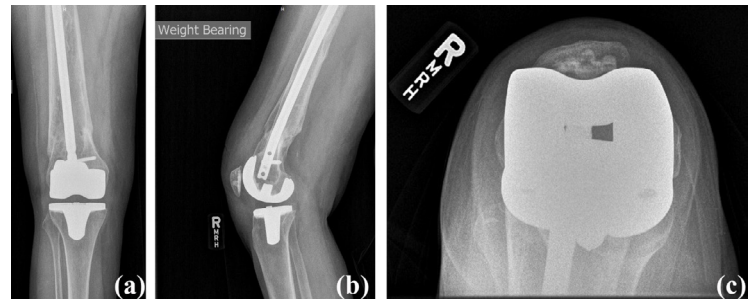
Case #2 post-operative radiographs: (a) anterior posterior view, (b) lateral view, and (c) sunrise view.
